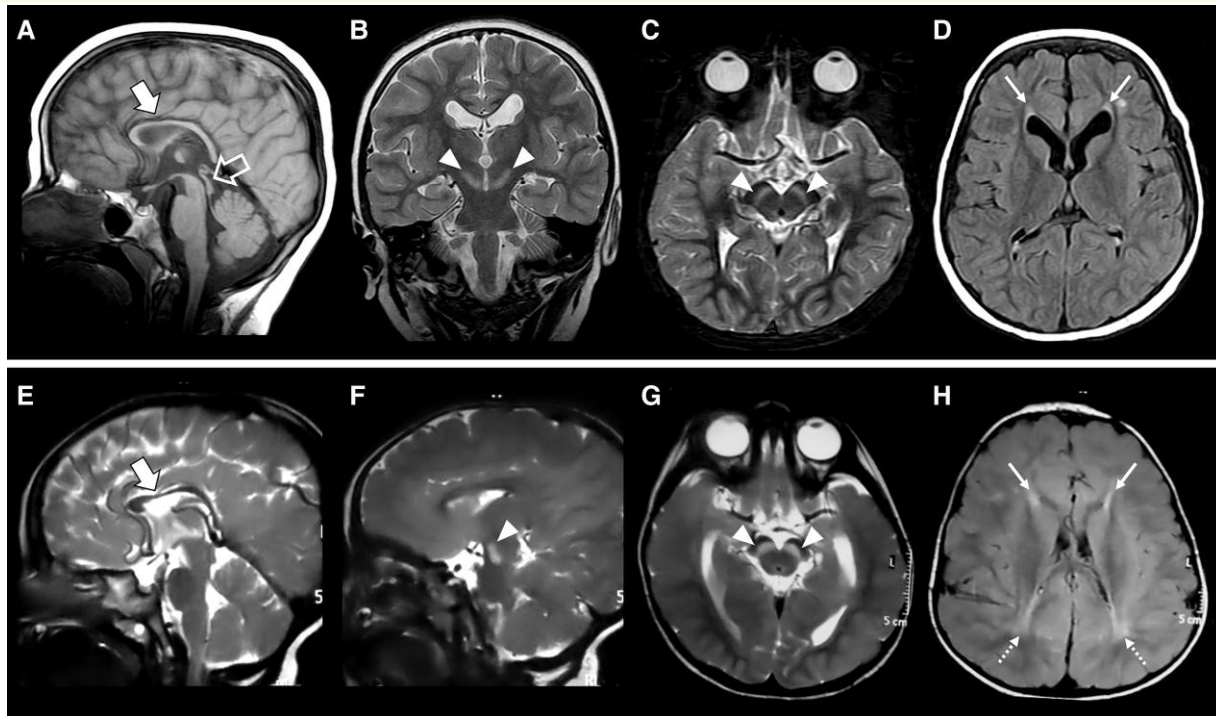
Neuroimaging features of LNP-related disorder. Brain MRI studies performed in Patient II:1 from Family 6 at 4 years of age (A–D) and in Patient II:2 from Family 7 at 2.5 years of age (E–H). Sagittal T₁- (A) or T₂-weighted (E) images demonstrate corpus callosum hypoplasia with prevalent involvement of the anterior portions (thick arrows). Coronal (B), axial (C, G) and sagittal (F) T₂-weighted images reveal symmetric marked T₂ hyperintensity of the substantia nigra (arrowheads). Note the ‘ears-of-the-lynx’ sign (thin arrows) on axial FLAIR images (D, H) consisting of hyperintense signal of the forceps minor bilaterally, which resembles the shape of the ears of a lynx with their characteristic apical hair tuft. Additional posterior periventricular white matter signal alterations are noted in Patient II:2 from Family 7 (dotted arrows). A short midbrain is also visible in Patient II:1 from Family 6 (empty arrow).
